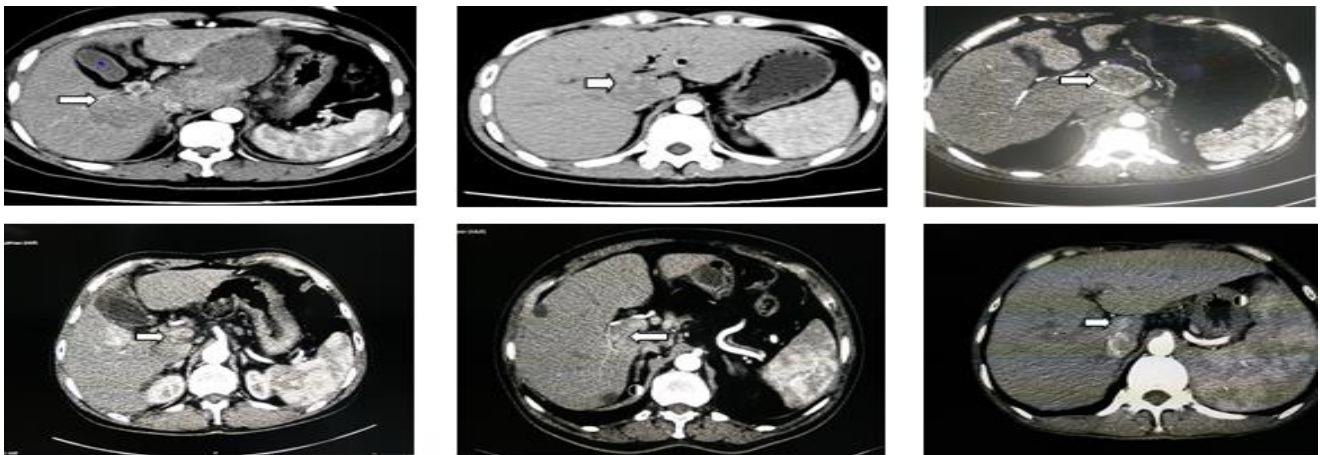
The arterial phase CT images of hepatocellular carcinoma in the caudate lobe.
